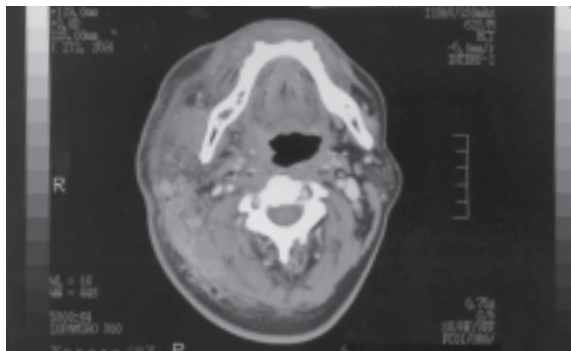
CT scan showing reticulation of the subcutaneous tissue on the right neck and thickening of the right platysmus and sternocleidomastoid muscles.
